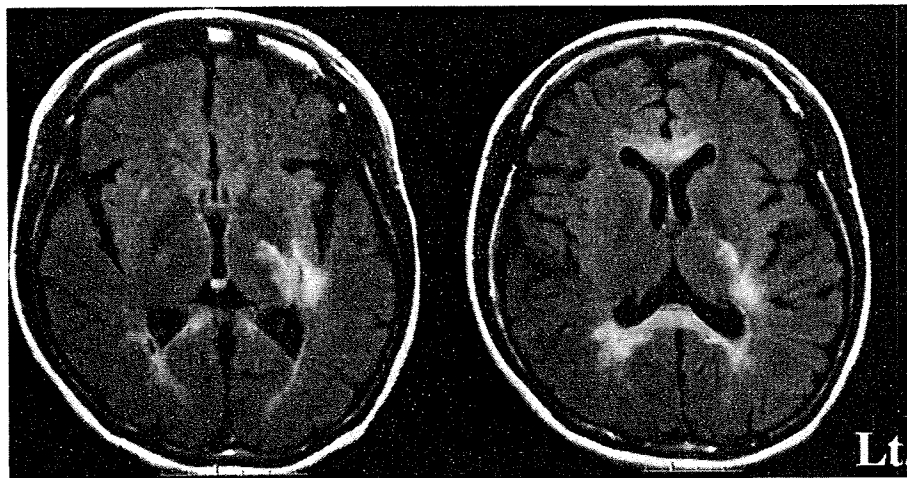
Brain MRI (fluid attenuated inversion recovery images) at age 27 revealed presented similar findings to 6 years before.
